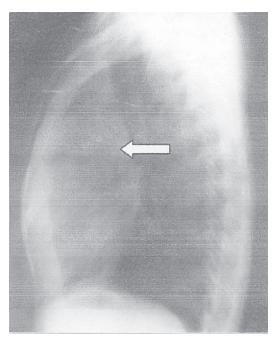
Chest X-ray lateral view mediastinal cyst located in the anterior compartment.
